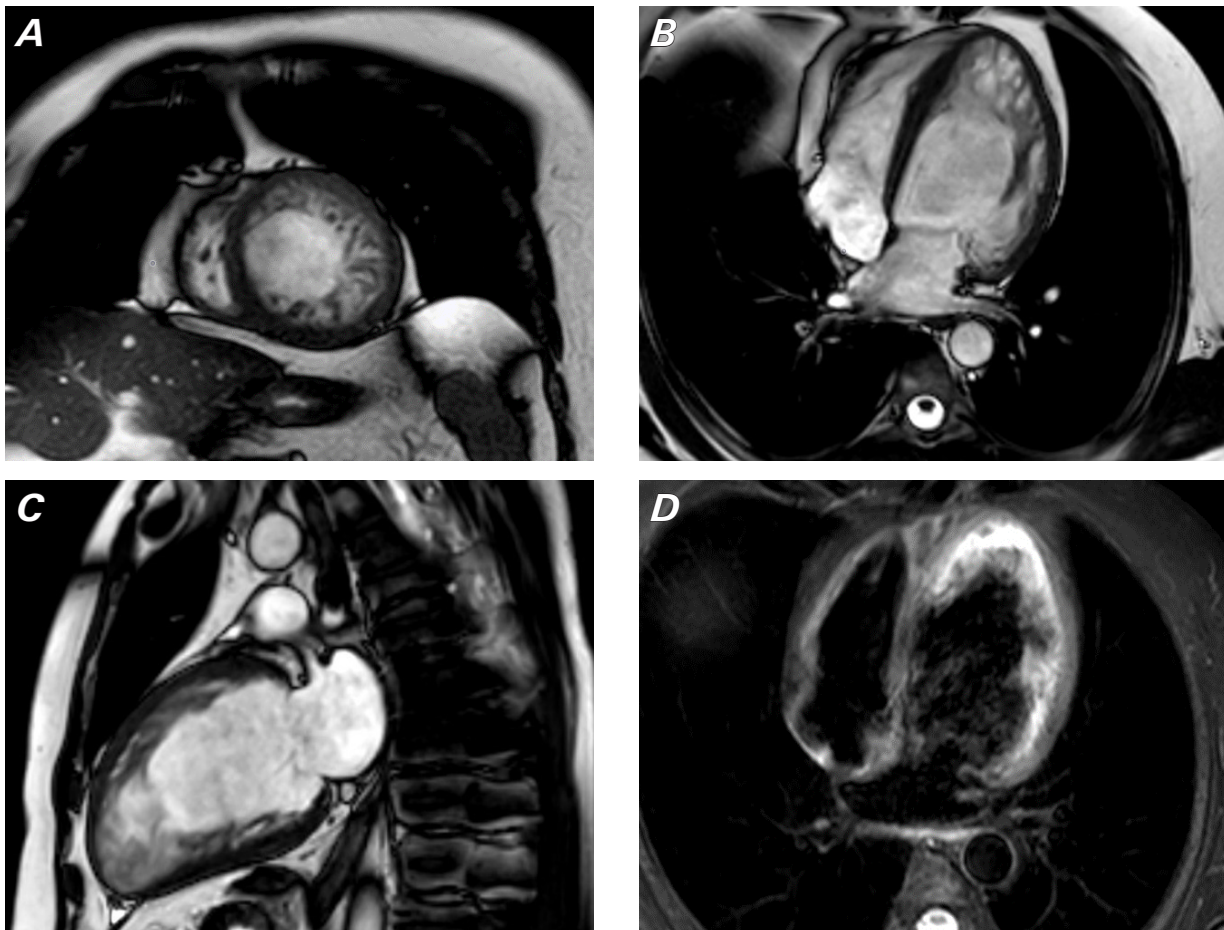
Cardiac magnetic resonance imaging shows A) multiple hypertrabeculation as displayed in short-axis view. B) The end-diastolic ratio between noncompacted and compacted layers of more than 2.3 at the apex/midlateral areas in a 4-chamber view is diagnostic for left ventricular noncompaction. C) Spongiform appearance of the left ventricular apex in a 2-chamber view. D) Increased signal intensity caused by the blood pool of trabecular recesses on late gadolinium enhancement 4-chamber view.
